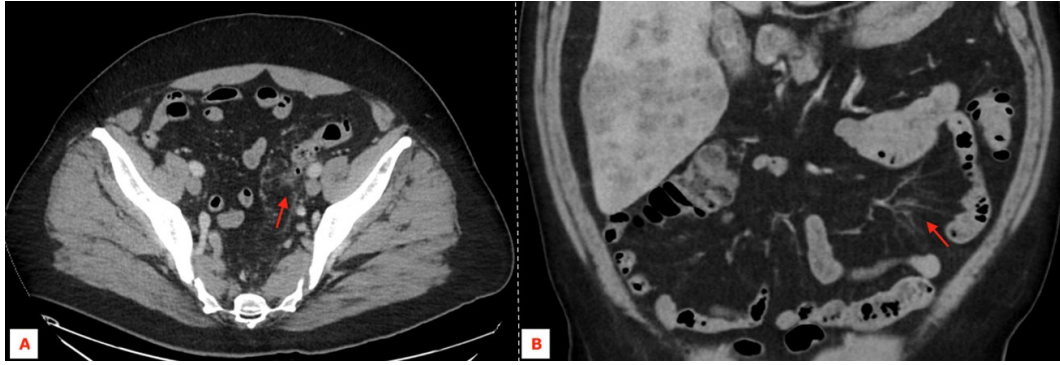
Computed tomography after intravenous contrast, in the venous phase, in the axial plane (A), has demonstrated colonic diverticulosis at the transition from the descending colon to the sigmoid colon, coexisting with slight fat densification around some diverticula, which presented evident parietal thickening, aspects suggestive of acute diverticulitis. No extraluminal gas or locoregional or intra-abdominal abscessed collections (Hinchey classification grade Ia) were documented. In the coronal plane (B), vascular engorgement was also identified, reflecting the greater need for vascular supply in inflammatory processes.
